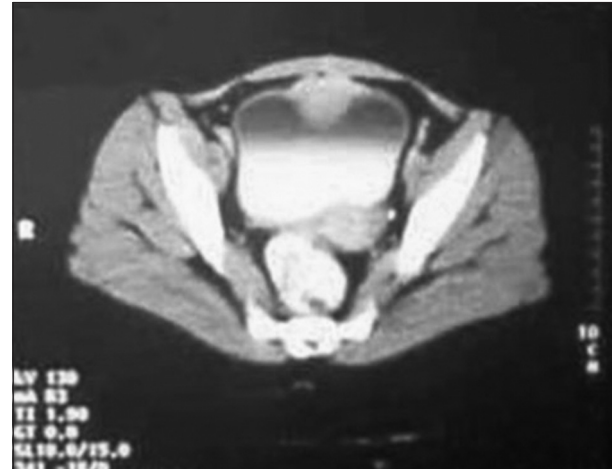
Contrast enhanced computed tomography showing anterior wall bladder mass
